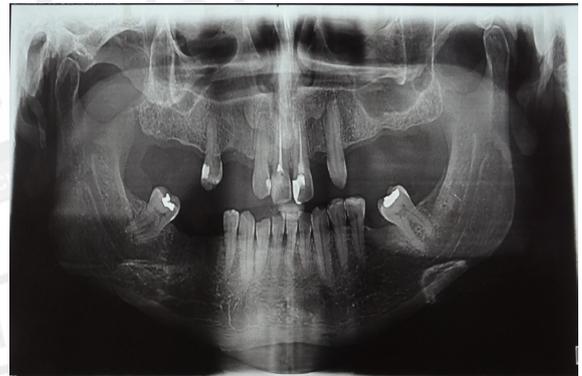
Orthopantomogramgraph
